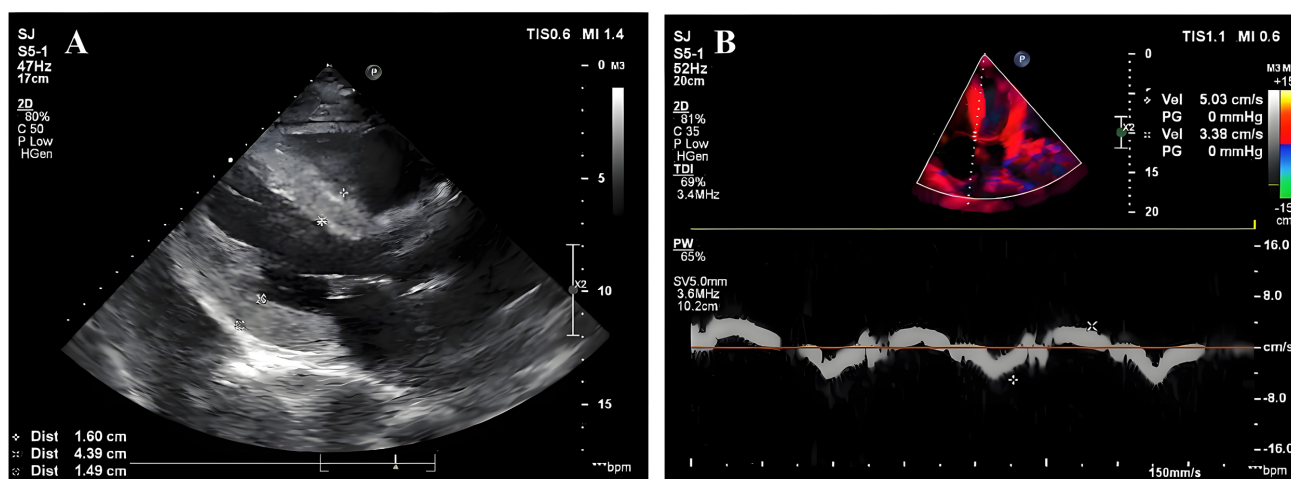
Echocardiography. (A) Parasternal long-axis view demonstrating a thickened interventricular septum (16 mm) with a granular sparkling appearance, a characteristic echocardiographic feature of amyloid cardiomyopathy. (B) Pulsed-wave tissue Doppler imaging at the lateral mitral annulus showing reduced e' (5 cm/s) and s' (3 cm/s) velocities.
